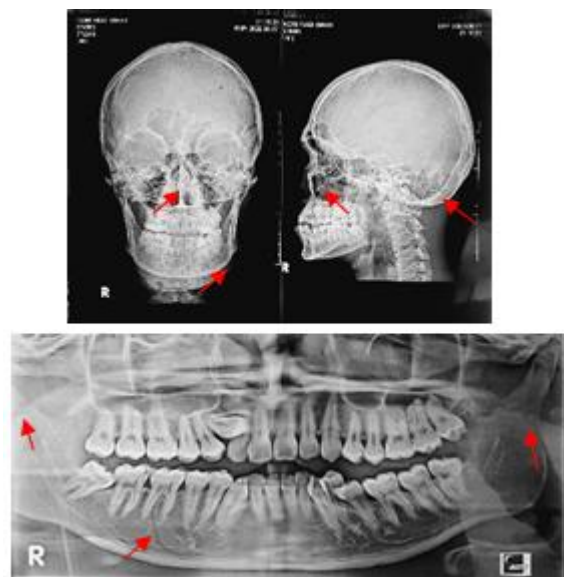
AP Lateral and Panoramic X-ray
